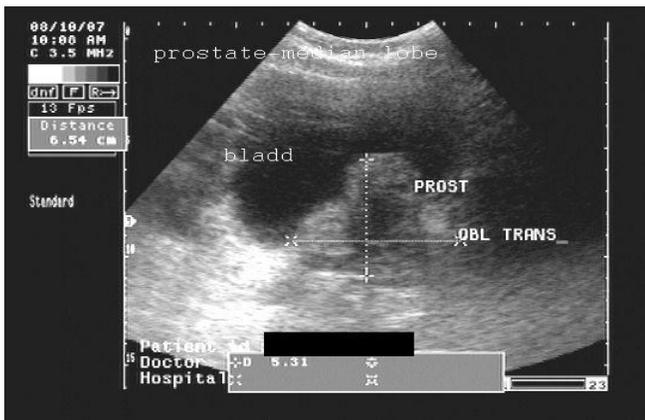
Abdominal Sonographic Presentation of BPH.
